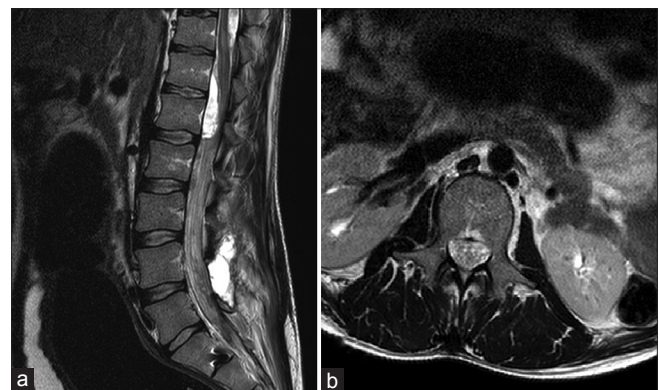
(a) T2 sagittal MRI: high signal fluid collection compressing/displacing the conus posteriorly. Note the irregularly thickened/clumped together nerve roots. (b) T2 sagittal MRI: irregularly thickened/clumped together nerve roots of the cauda equina
